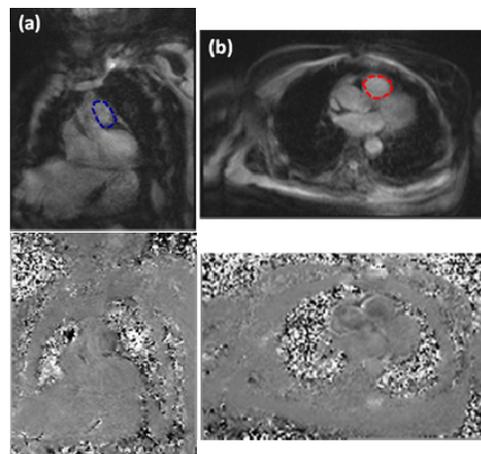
Magnitude and velocity mapping from one out of six subjects using real-time PC-MRI with SVE reconstruction on (a) pulmonary and (b) systemic circulation. Magnitude images offer the capability to depict ROI on main pulmonary artery (ROI in blue) and ascending aorta (ROI in red) to analyze flow volumes and shunt ratios.
